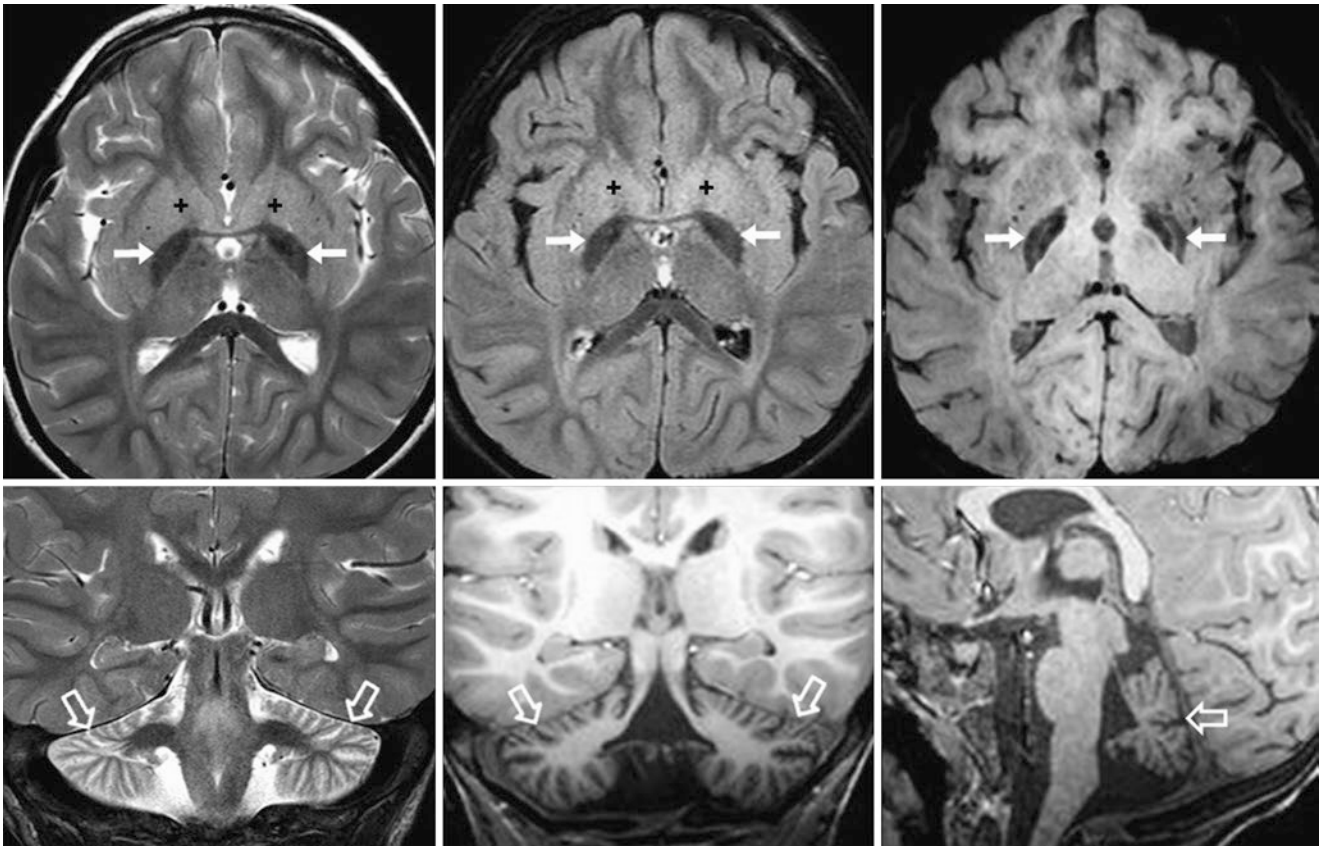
Comparison case of NBIA: infantile neuroaxonal dystrophy (INAD). After being diagnosed with INAD as an infant, a 3 year old underwent a 3T MRI that showed abnormally dark GP (arrows) on T2WI (top left), FLAIR (top middle), and SWI (top right). There was severe cerebellar atrophy (open arrows), as noted on coronal T2WI (bottom left), T1WI (bottom middle), and sagittal T1WI (bottom right), consistent with the diagnosis of INAD. There was also probably mild edema within the caudate and putamen nuclei (+), as shown on T2WI and FLAIR
